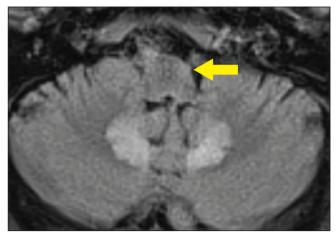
Magnetic resonance imaging shows T_2 hyperintensity of left inferior olivary nuclei.
